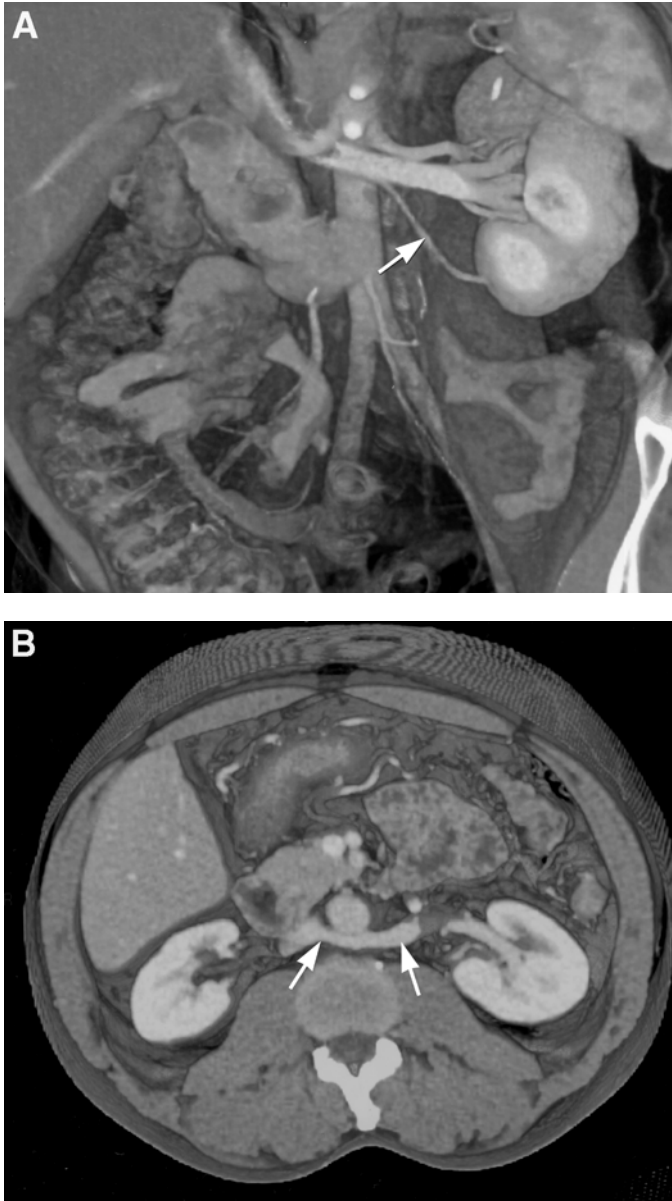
Three-dimensional CT angiography demonstrating (A) a second left lower pole renal artery (white arrow) and (B) a retroaortic left renal vein (white arrows) in two separate donor patients.
